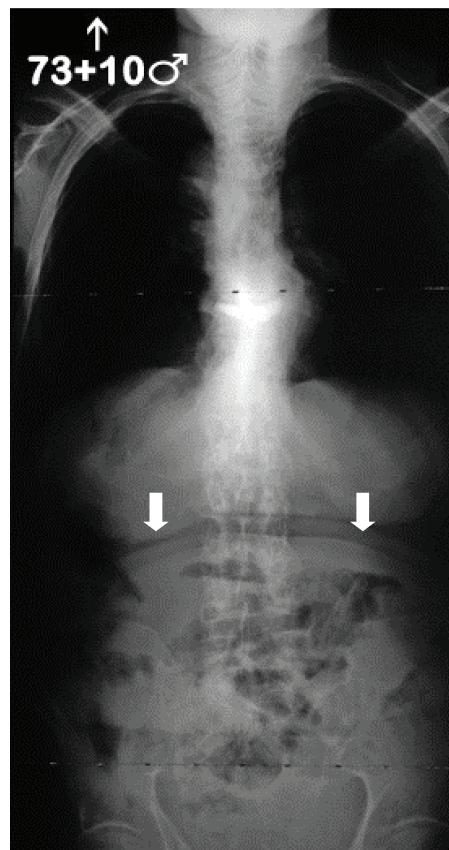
Standing preoperative coronal radiograph showing the cement from the vertebroplasty and the abdominal crease from his kyphosis (arrows).
